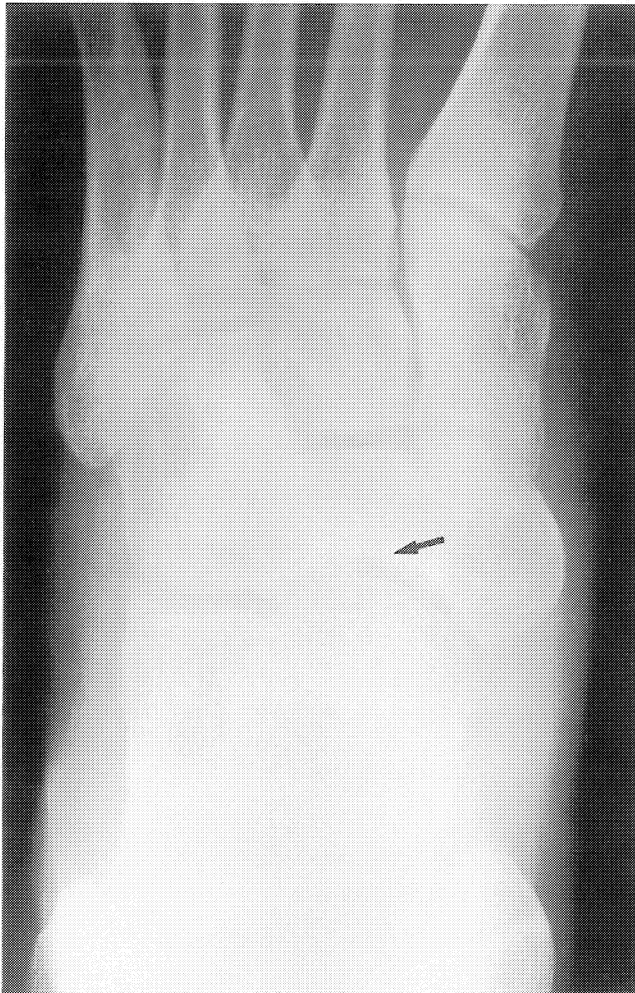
AP radiograph demonstrates very subtle abnormality of the tarsal navicular with involvement of the talonavicular joint (arrow).
